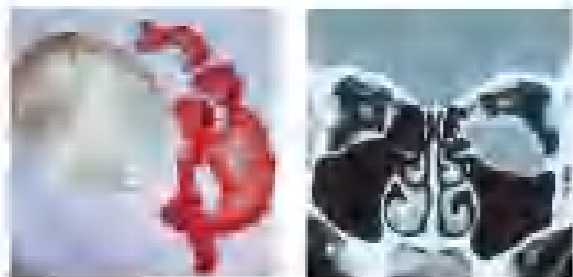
Left, The large orbital cystic soft-tissue mass removed from patient 2 during orbitotomy. Right, Coronal CT of patient 2 demonstrating a soft-tissue mass arising from the inferomedial aspect of the left orbit.
